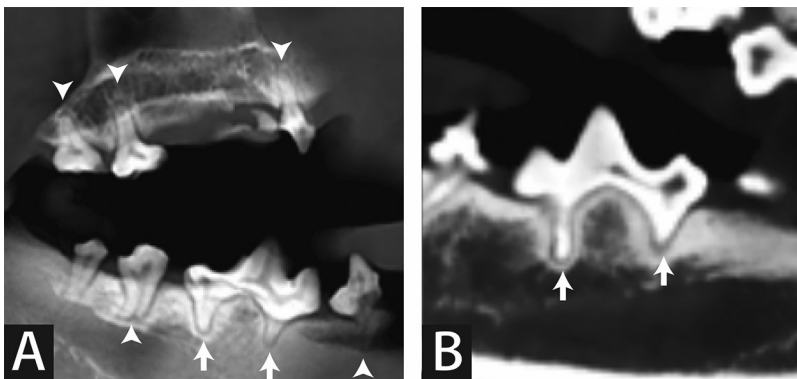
Sagittal plane CBCT images of right (A) and left (B) mandibular and maxillary teeth. The mandibular first molar teeth have severe root hypoplasia (arrows), and the roots of the remaining multirooted premolar and molar teeth shown here are convergent, conrescent, or fused (arrowheads).
